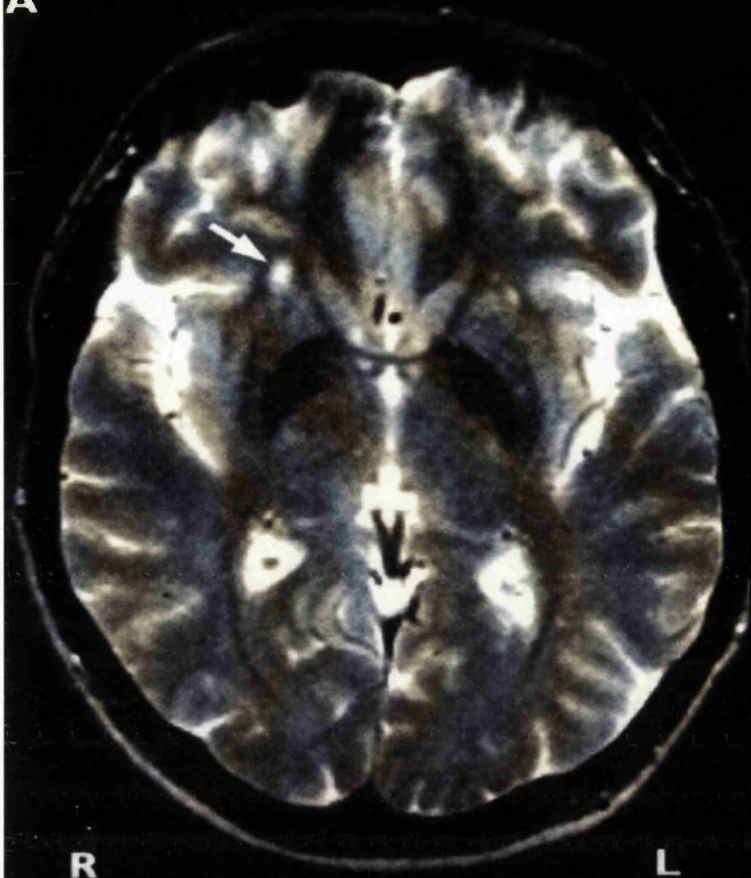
A) T2-weighted MRI, 6 months after acute onset of left arm tremor, shows an ischaemic lesion in anterolateral aspect of the right putamen (arrow).
